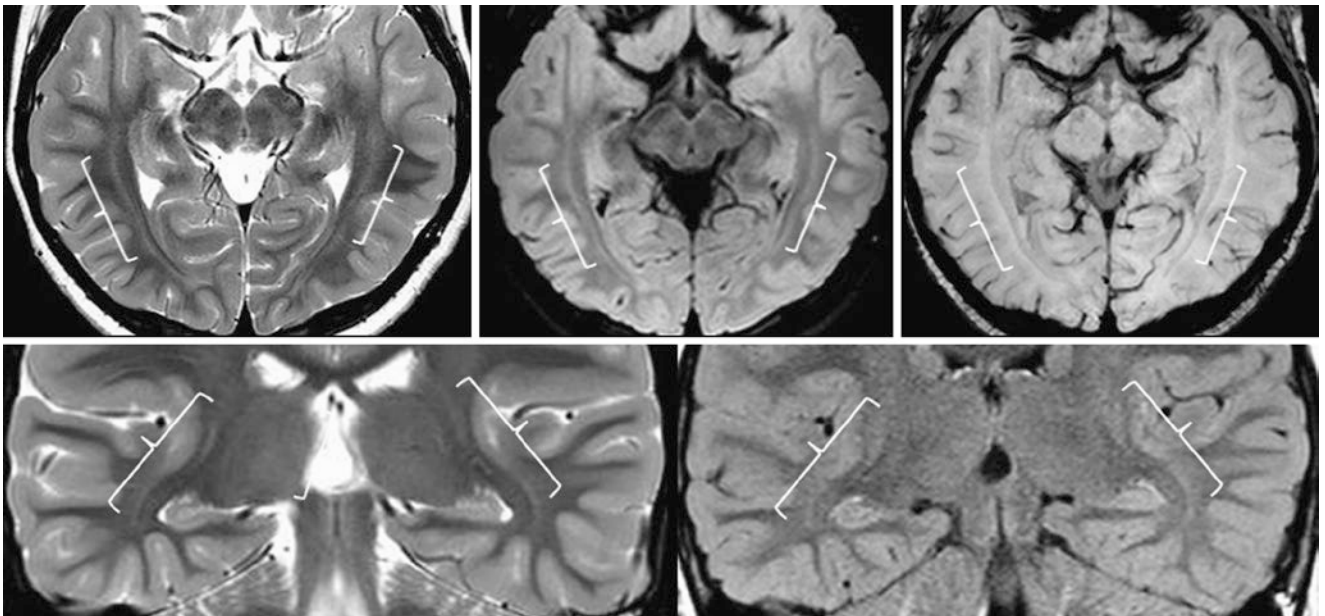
A 4.5-year-old with a solitary seizure. 3T axial SE T2WI (top left), 3D FLAIR (top middle), and SWI (top right), coronal T2WI (bottom left), and FLAIR (bottom right) were all normal. Note the continuity and continuity of the terminal zones bilaterally within the optic radiations (brackets) on T2WI and FLAIR, without a corresponding abnormality on SWI
